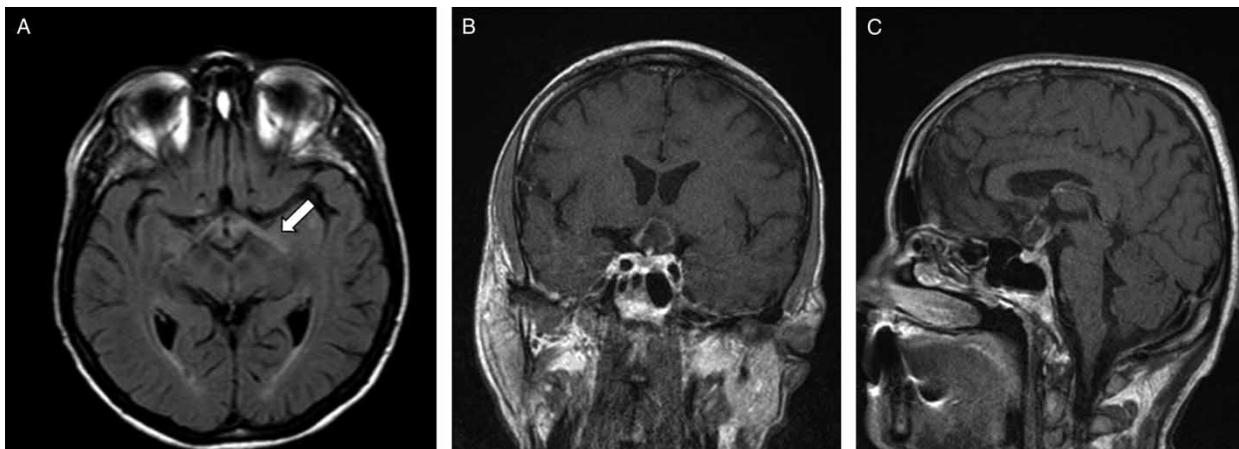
Representative MRI slices demonstrating the temporal dynamics of lesion evolution in one panel. MRI performed on 14 February 2007 showed high signal intensity and swelling of predominantly the left optic tract (arrow) (A). MRI performed on 23 February 2007 showed development of a mass lesion within and above the optic chiasm with extension into the left basal ganglia; contrast enhancement at the borders of the expansile lesion (B and C).
